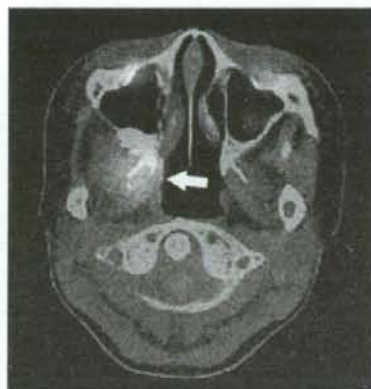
A 13-year-old girl with second primary osteosarcoma following remission of embryonal rhabdomyosarcoma. Transverse FDG PET/CT image shows abnormal uptake in the right masticator space, which corresponds to previously irradiated area for primary tumor (arrow). Also noted is abnormal ossification with the tumor
